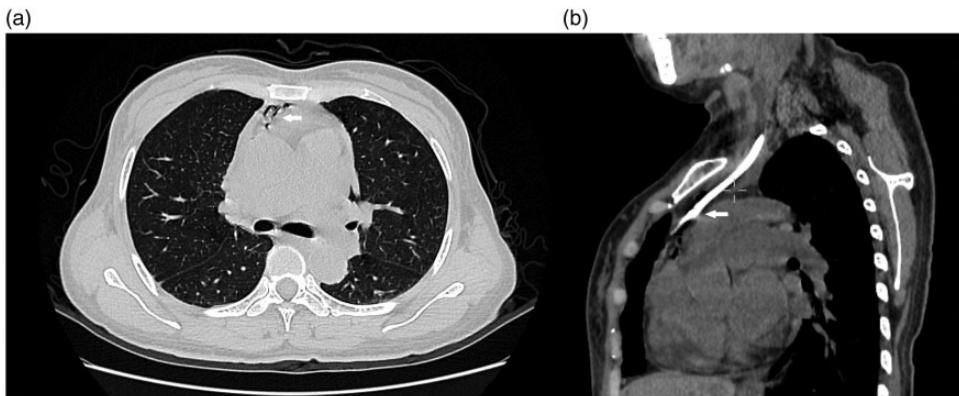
(a) Axial and (b) coronal computed tomographic images of the chest show the anterior mediastinum. There is a small amount of pneumomediastinum in the mediastinum, while the corresponding fat tissue is not clear. The lower part of the catheter (arrowhead) penetrates into the anterior superior mediastinum
